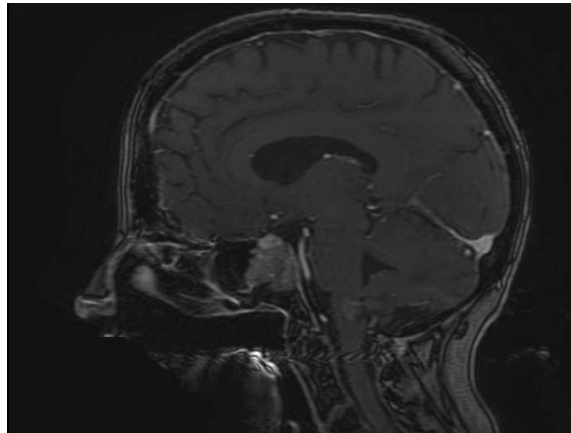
Contrast-enhanced brain MRI. Metastatic bone lesion in the clivus with an associated enhancing soft tissue mass measuring 2.8 x 2.3 cm, extending into the sphenoid sinus and the sella turcica-pituitary gland.
